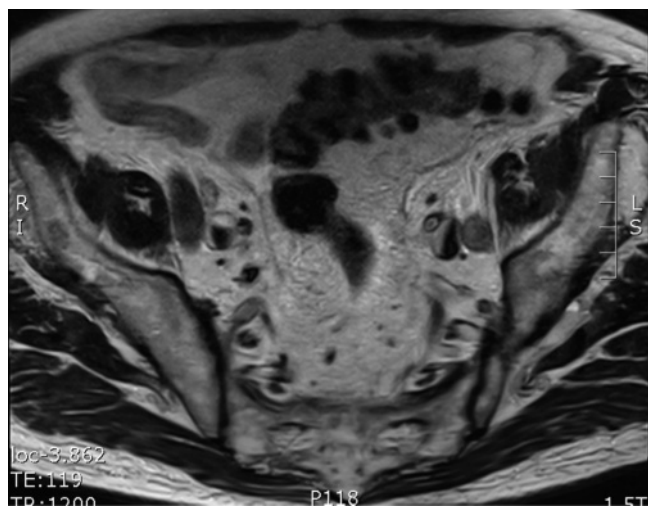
Diverticulosis. Transverse T2-weighted 3D SPACE image demonstrates multiple signal void sacculations arising from the sigmoid colon consistent with diverticulosis. Diverticula are common and often incidental findings. Complications of diverticula include diverticulitis and frank abscess.
